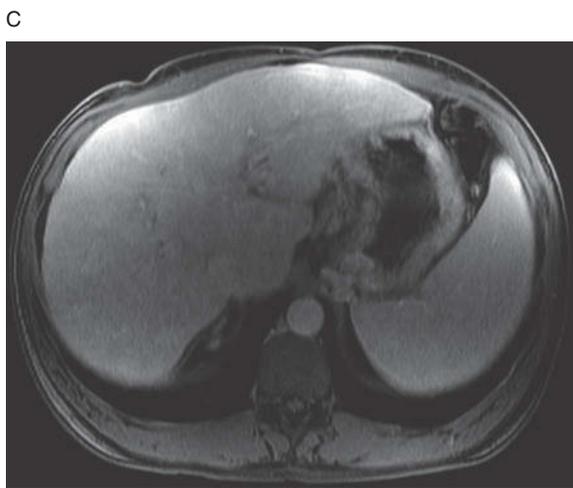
Perfusion changes in cirrhotic liver. Axial T2-weighted image (A) demonstrates subtle foci of peripheral, wedge-shaped increased T2 signal (arrows). Axial T1-weighted, fat-saturated arterial-phase image (B) shows brisk enhancement of these predominantly peripheral, wedge-shaped lesions with no evidence of washout on delayed image (C). This is a dramatic example and was worrisome enough in this cirrhotic patient (note nodular contour to liver surface) to warrant follow-up but were these truly HCC's, one would expect an abnormal delayed phase. Follow-up exam was unchanged.
